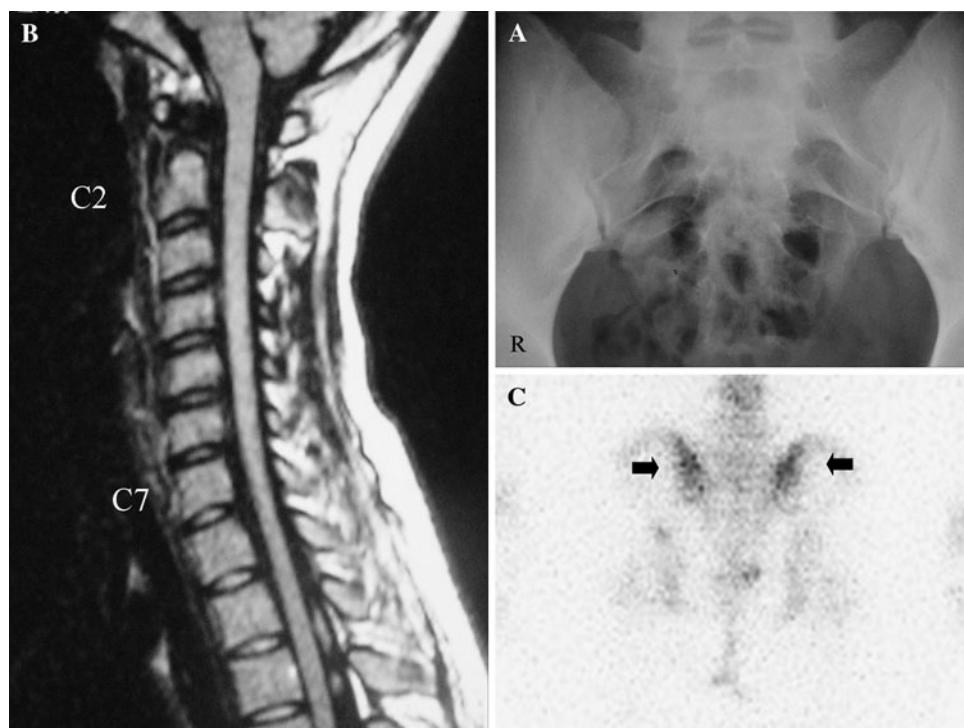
Radiography showed equivocal reactive change at sacroiliac joints (a). Spinal magnetic resonance imaging revealed cord atrophy at C5-T1 level (b). One year later, scintillography disclosed radioisotope uptake at bilateral sacroiliac joints (arrow) (c). *R* right side
